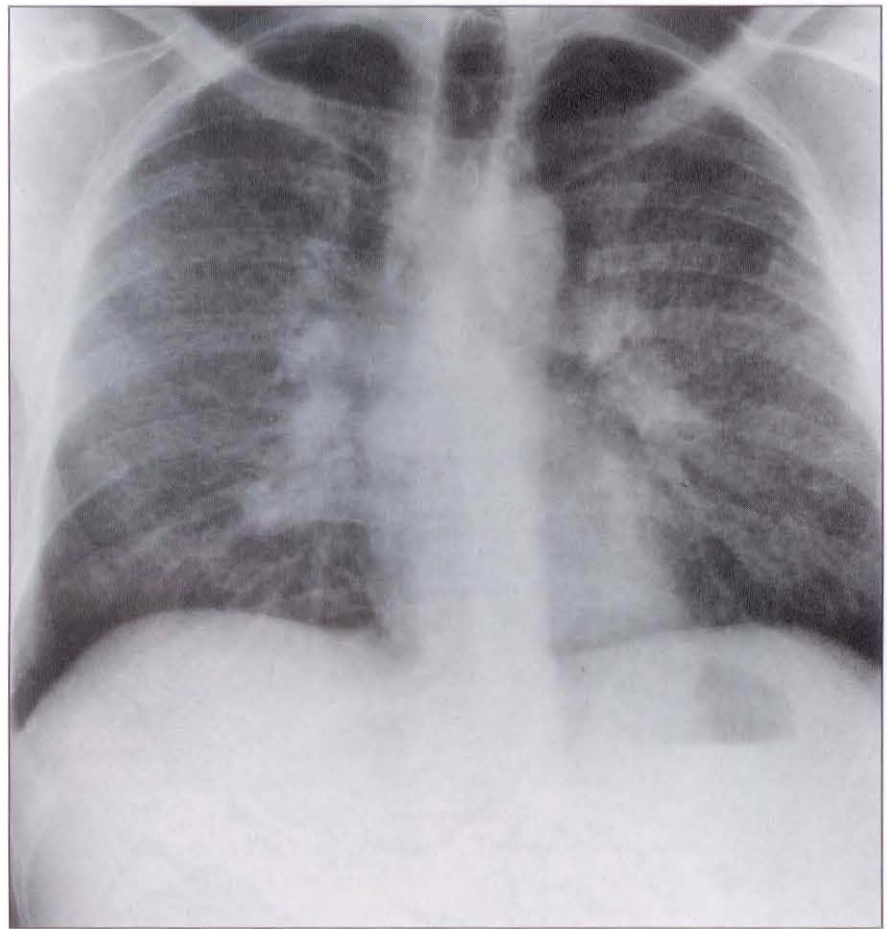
Chest x-ray showing reticulonodular interstitial pattern and bilateral hilar adenopathy
